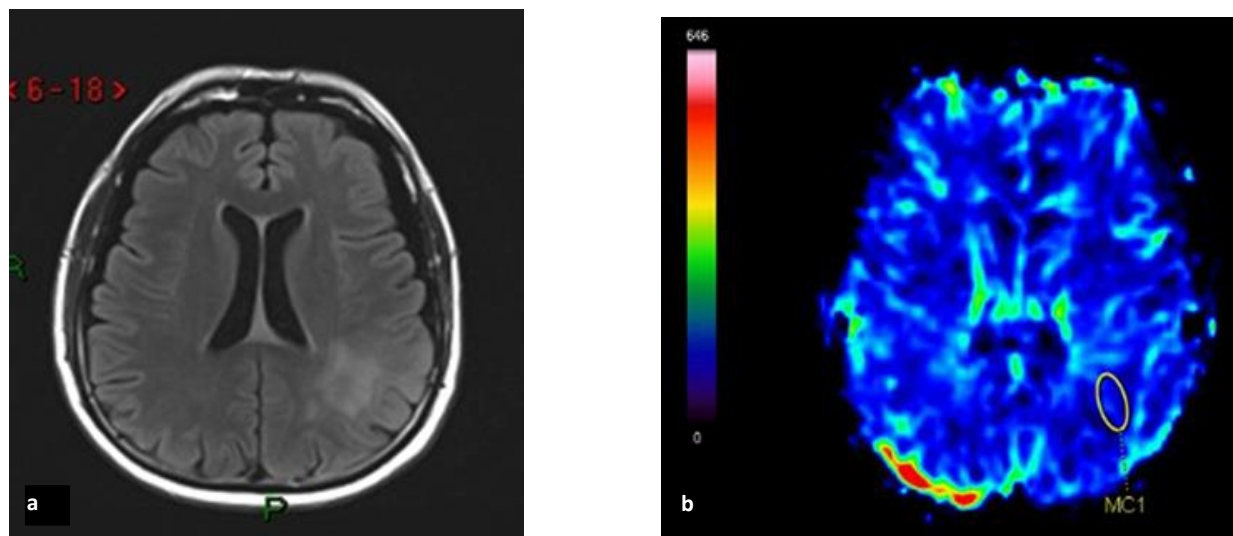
Follow up MRI of a patient with known left parietal glioma; a) axial FLAIR image showing abnormal hyper intense in left parietal lobe; however the subsequent post process perfusion image(b) shows comparable perfusion dynamics with rest of the normal brain parenchyma suggesting no residual/recurrent disease.
